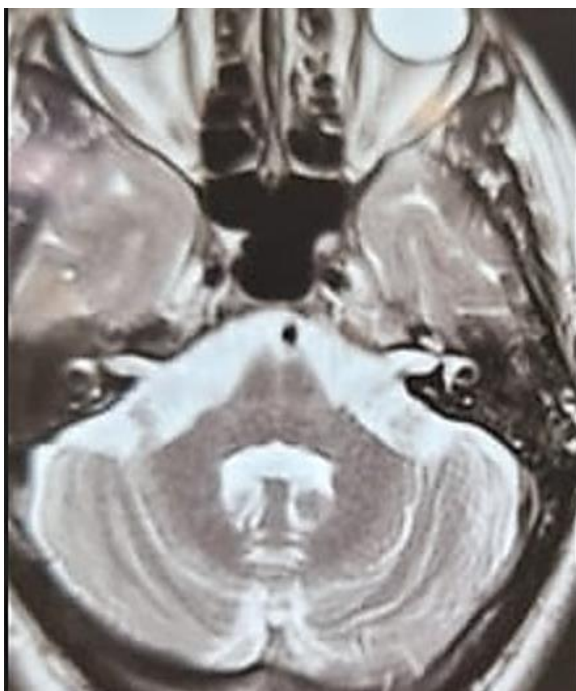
MRI Flair Axial view showing hot cross bun sign and cerebellar atrophy.
